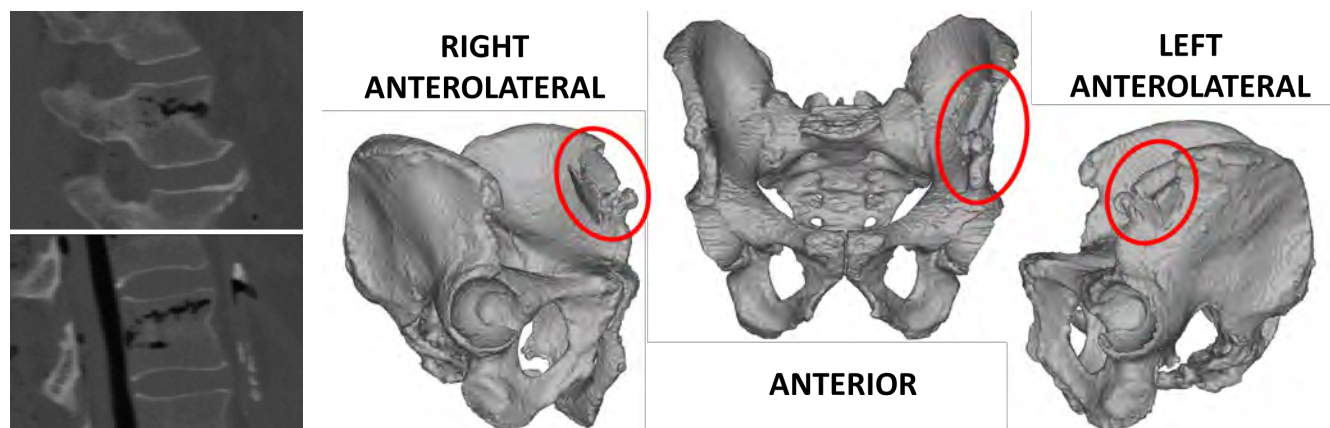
Post-test sagittal view CT images of the L1 vertebral compression fracture observed in the female (left) and the left iliac wing fracture observed in the male (right).
